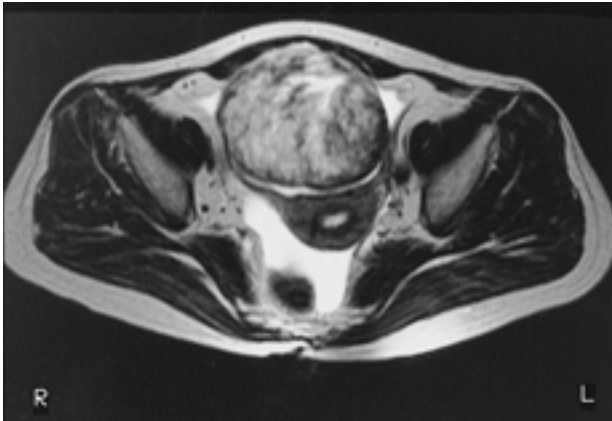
Magnetic resonance images show an unhomogeneous mass with predominantly high signal intensity on T2-weighted image.
